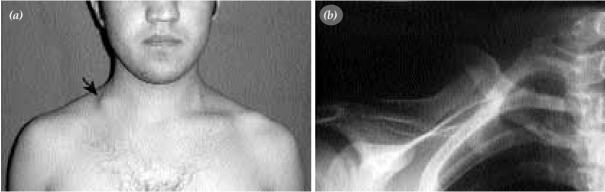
Preoperative (a) clinical and (b) radiographic appearance of the patient.
